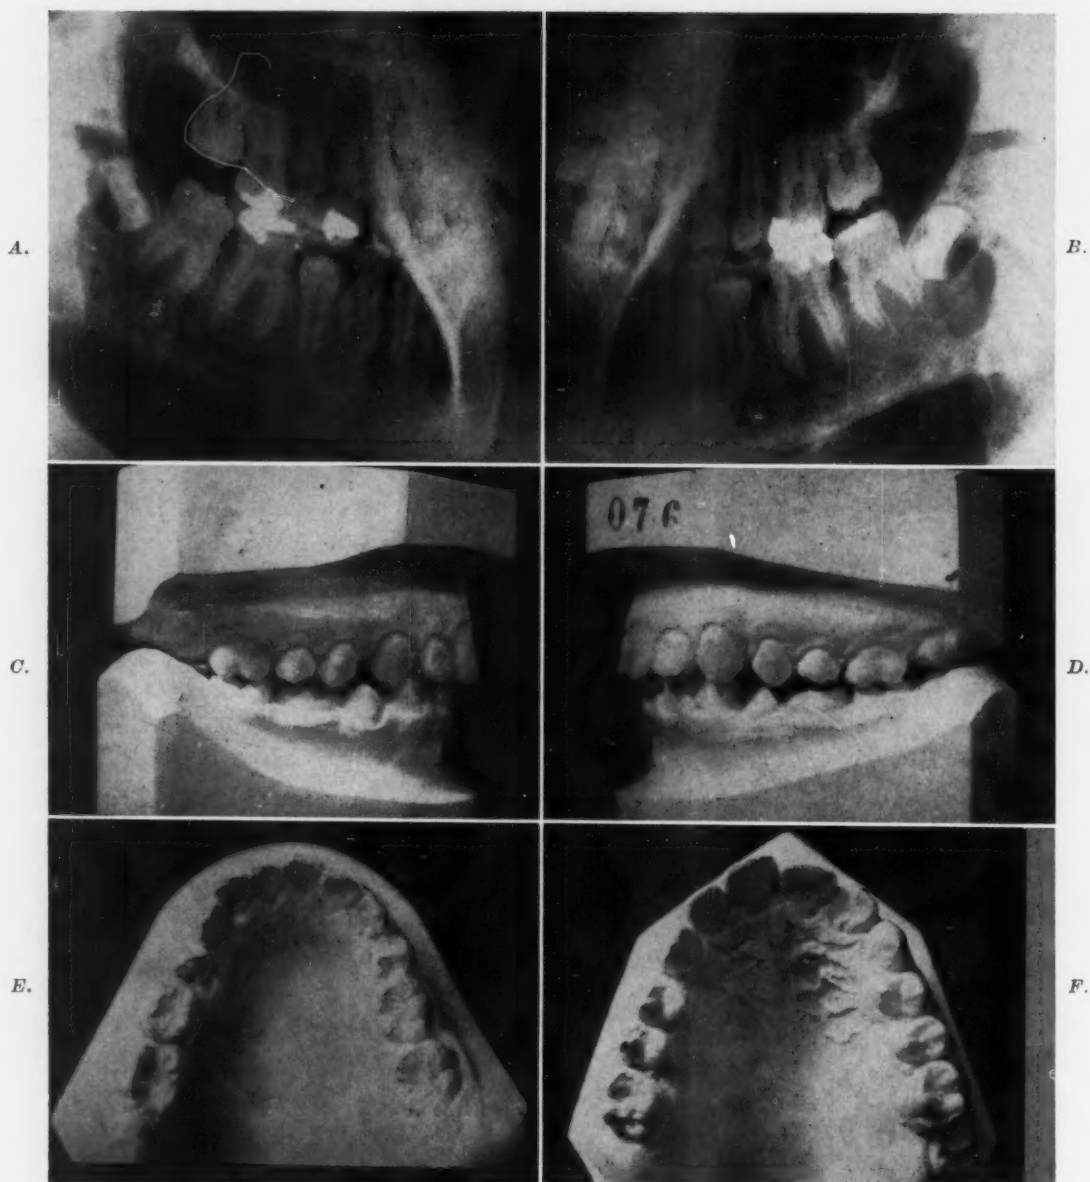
A* and *B*, Left and right lateral jaw roentgenograms showing presence of over-retained mandibular second deciduous molars, fully calcified second premolars, and erupting permanent second molars. *C* and *D*, Left and right views of study casts of same mouth showing excessive width of deciduous second molars in mandibular arch. *E* and *F*, Occlusal views of mandibular and maxillary study casts of same mouth showing developing crowding of mandibular incisors and resulting displacement of maxillary right permanent central incisor.
